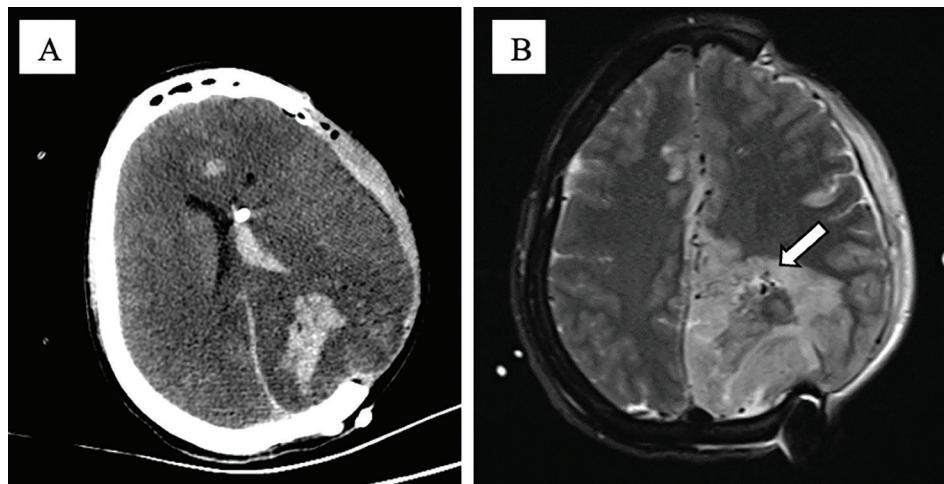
(A) Cerebral CT scan: postoperative left frontotemporoparietal decompressive craniotomy. (B) Postoperative MRI: hemorrhagic area in the left parieto-occipital region and arteriovenous malformation nidus (arrow)
